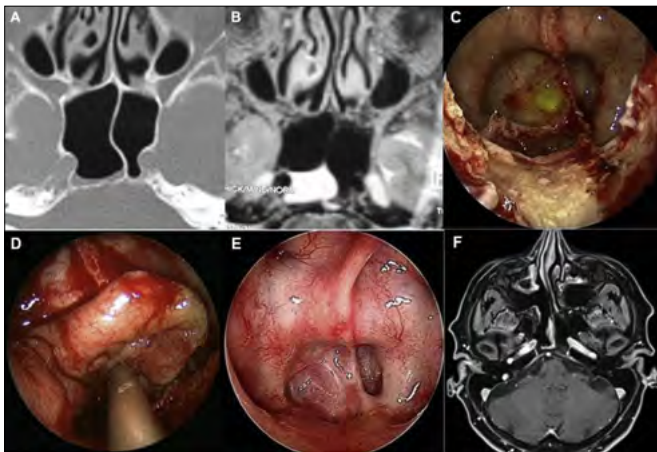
Computed tomography (A) and T2-weighted MRI (B) in a patient with a right clival spontaneous cerebrospinal fluid leak. Intraoperative endoscopic view showing a paraseptal approach: the sphenoidotomy is enlarged to gain adequate access to the sinus, and the intersinus septum is drilled out. The cerebrospinal fluid leak with small meningocele can be clearly identified in the posterior wall of the sphenoid. The green colouration is due to the intraoperative use of fluorescein (C). Intraoperative view of the nasoseptal flap placed overlay within the posterior wall of the sphenoid sinus, covering the clival area (D). Endoscopic endonasal view 24 months after surgery (E) and postoperative axial T1-weighted MRI scan with gadolinium showing a nasoseptal flap covering the clival area on the right sphenoid sinus (F).
